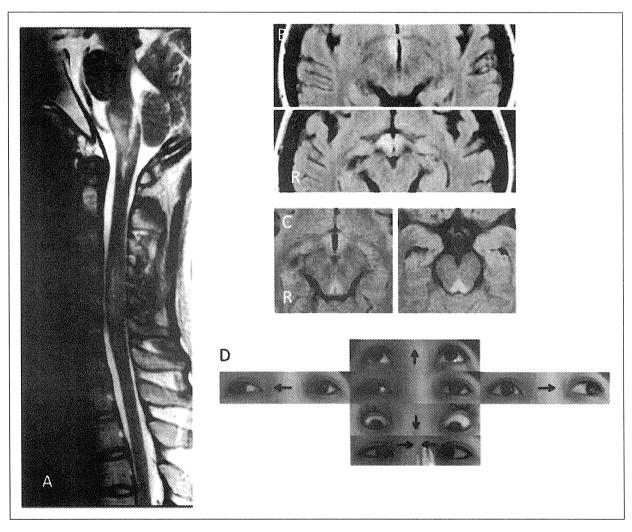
T2-weighted image ($TR = 2500 \, \text{ms}$, $TE = 108 \, \text{ms}$) at the first admission demonstrates a continuous hyperintense lesion from the medulla to C1, and a longitudinally extensive spinal cord lesion from C4 to C7 (\mathbf{A}). FLAIR images ($TR = 9000 \, \text{ms}$, $TE = 97 \, \text{ms}$) show band-like hyperintense lesions in the hypothalamus bilaterally (B). MRI at the time of appearance of WEBINO syndrome shows a high signal intensity lesion in the midbrain tegmentum adjacent to the aqueduct on FLAIR images ($TR = 9000 \, \text{ms}$, $TE = 110 \, \text{ms}$) (\mathbf{C}). Photographs of ocular movement demonstrating exotropia of either eye in the primary eye position and an adduction deficit of either eye on attempted lateral gaze (\mathbf{D}). Convergence is intact. The arrows indicate the directions of attempted gaze. FLAIR: fluid-attenuated inversion recovery, WEBINO: wall-eyed bilateral internuclear ophthalmoplegia.
